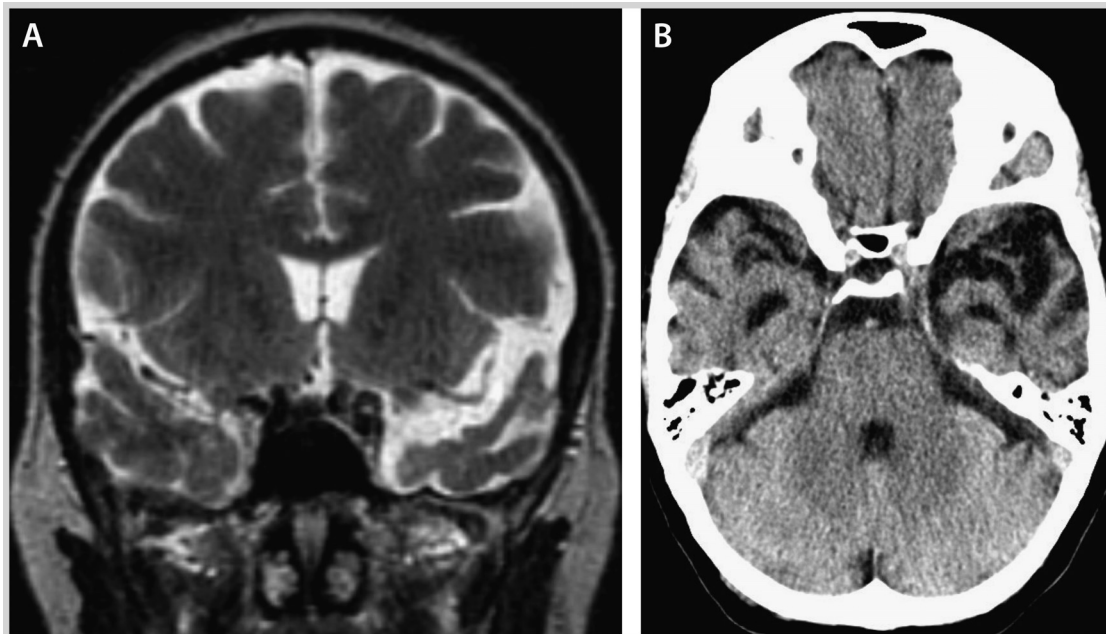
Imaging of the patient in Case 2-2. *A*, Coronal T2-weighted brain MRI showing focal atrophy of the left anterior temporal lobe. *B*, Axial head CT with bilateral anterior and inferior temporal lobe atrophy.
